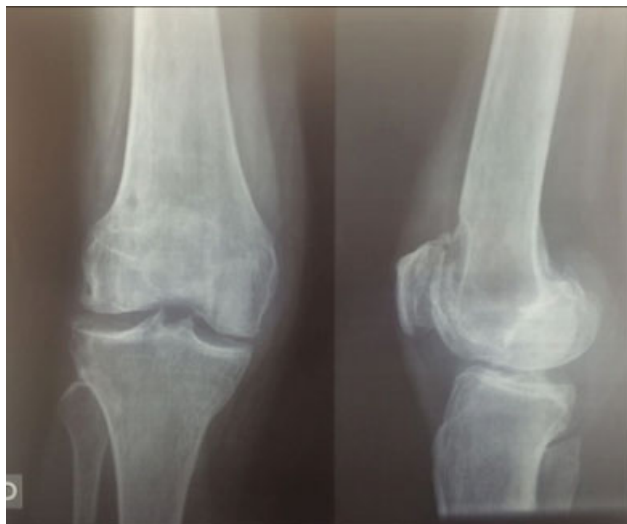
Post-reduction control radiographs.
